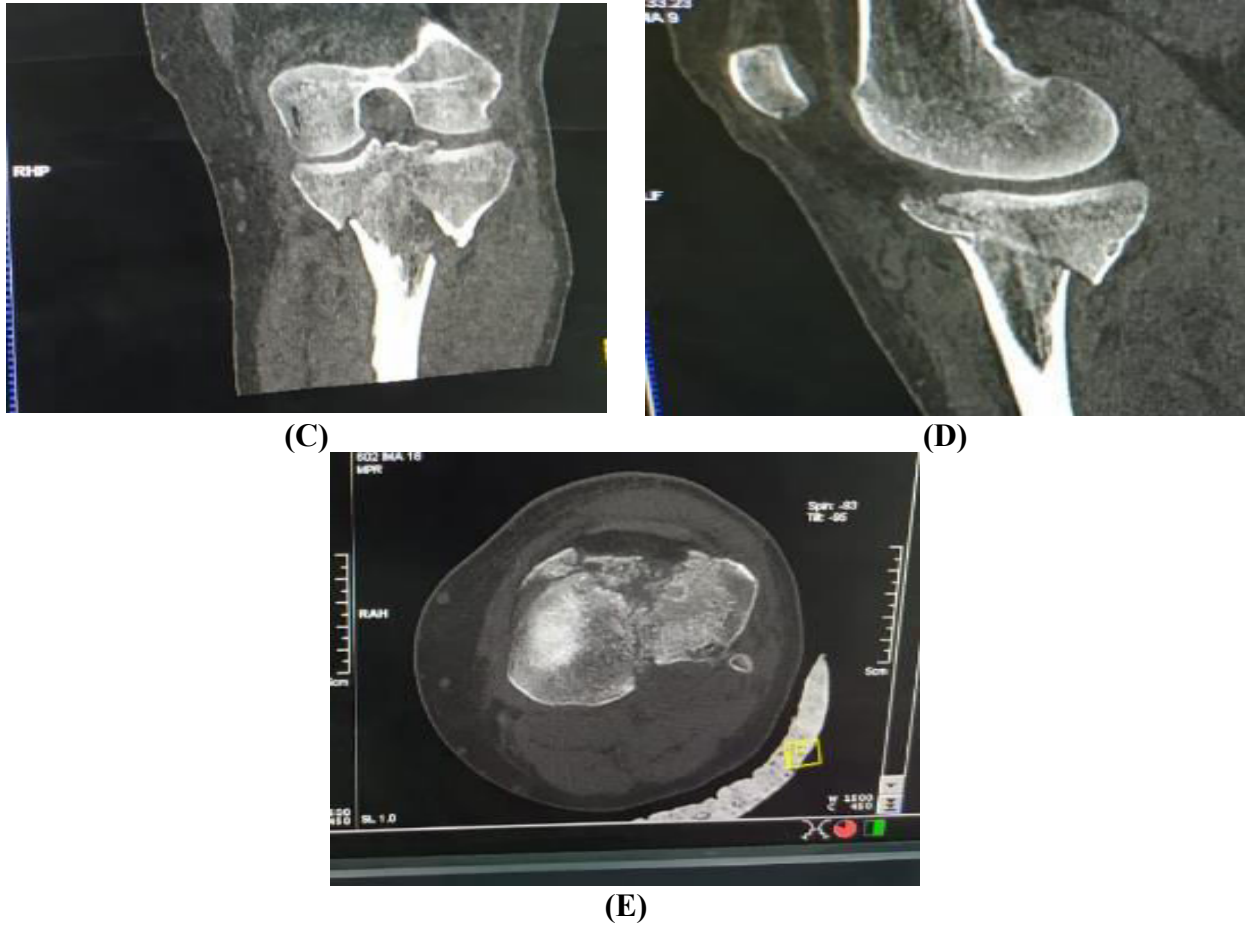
(A) 3D CT cuts, (B) 3D CT view, (C) CT cuts control view, (D) CT cut's sagittal view, (E) Ct axial view in knee
